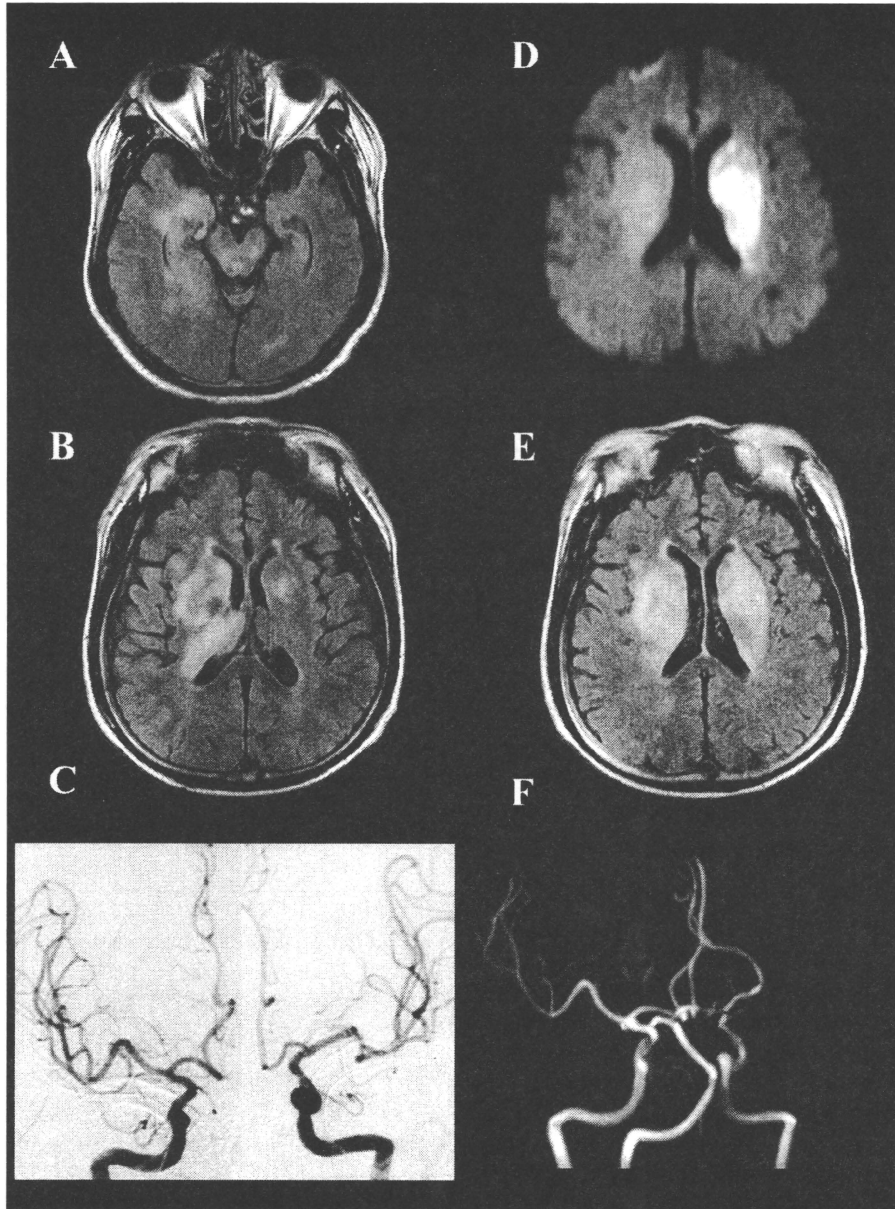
Radiological findings before (A-C) and after (D-F) cerebral infarction associated with HIT. (A, B) FLAIR images (TE/TR=124/9000, 1.5-T whole-body magnetic resonance system, Magnetom Sonata A.G., Siemens, Erlangen, Germany) obtained 9 days after disease onset (day 9) show hyperintense lesions in the right hippocampus, temporal lobe, and corona radiata. (C) Cerebral angiography done 3 days after disease onset shows no stenosis or occlusion in bilateral internal carotid arteries. (D) DWI (TR/TE=180/96, b=1,000 s/mm², matrix 128×128, field of view 230 mm) on day 23 shows a hyperintense lesion in the left corona radiata. (E) A FLAIR image on day 23 shows a hyperintense lesion in the corona radiata bilaterally. (F) Brain MRA on day 23 shows occlusion of the main trunk of the left middle cerebral artery.
